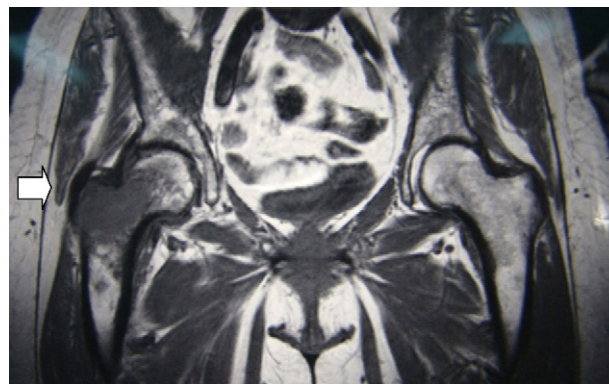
Magnetic resonance imaging in T1 showing a central and expansive image with aggressive characteristics located at the major trochanter and neck of the right hip (arrow).
